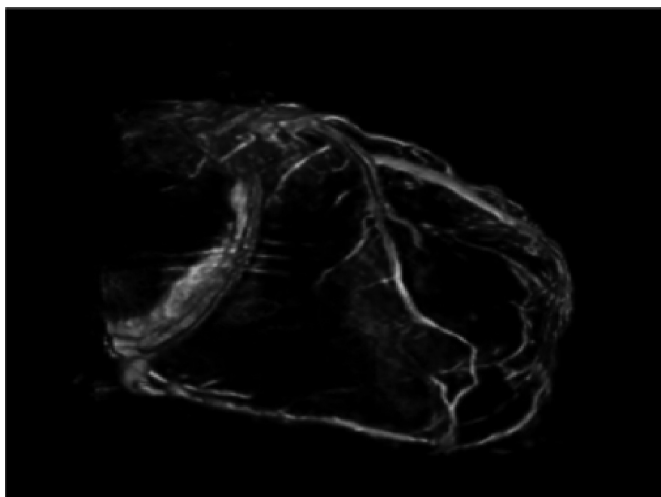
Visualization of the coronary sinus with 3D computed tomography (CT)-like imaging. The coronary sinus can be overlaid over live fluoro and thus offers the surgeons or interventionalists the ability to navigate live in 3D anatomy (3D-Roadmap). Imaging Courtesy of Dr. Gallagher, Central Baptist Hospital, Lexington, Kentucky, USA.
